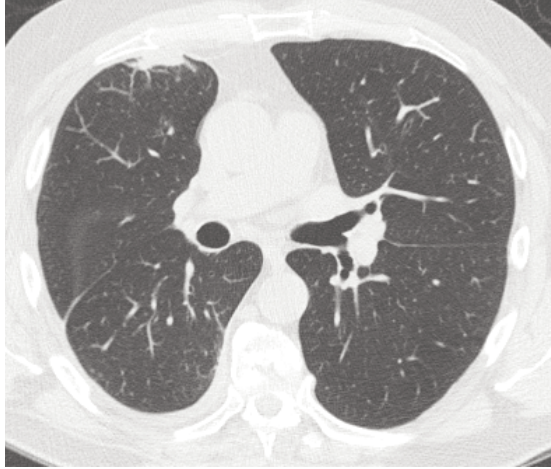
Chest CT of a 70-year-old man with IgG4-related autoimmune pancreatitis and pleural fibrosis. Chest CT scan demonstrated multiple regions of pleural thickening within the right hemithorax including focal nodular thickening anteriorly and more diffuse thickening posteriorly. Thoracoscopic pleural biopsy demonstrated sclerosing pleuritis with dense lymphoplasmacytic infiltrates containing >30 IgG4⁺ cells per high power field.
